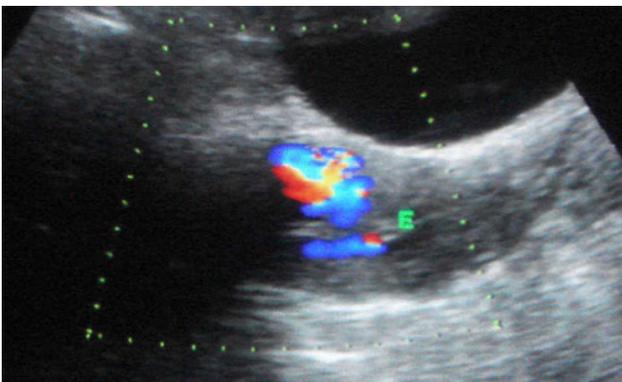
Increased vascularity and turbulent flow on Doppler suggestive of AV malformation
